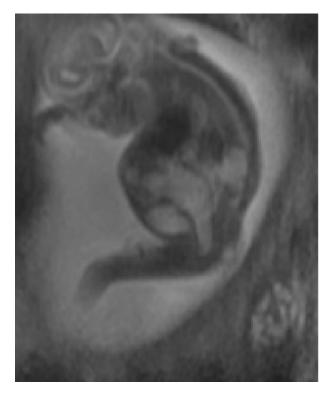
Fetal MRI image in saggittal view of a fetus with cloaca demonstrating hydronephrosis, hydrocolpos, and dilated rectum. (*Provided by Marc Levitt, MD, Colorectal Center for Children, Cincinnati Children's Hospital.*)
